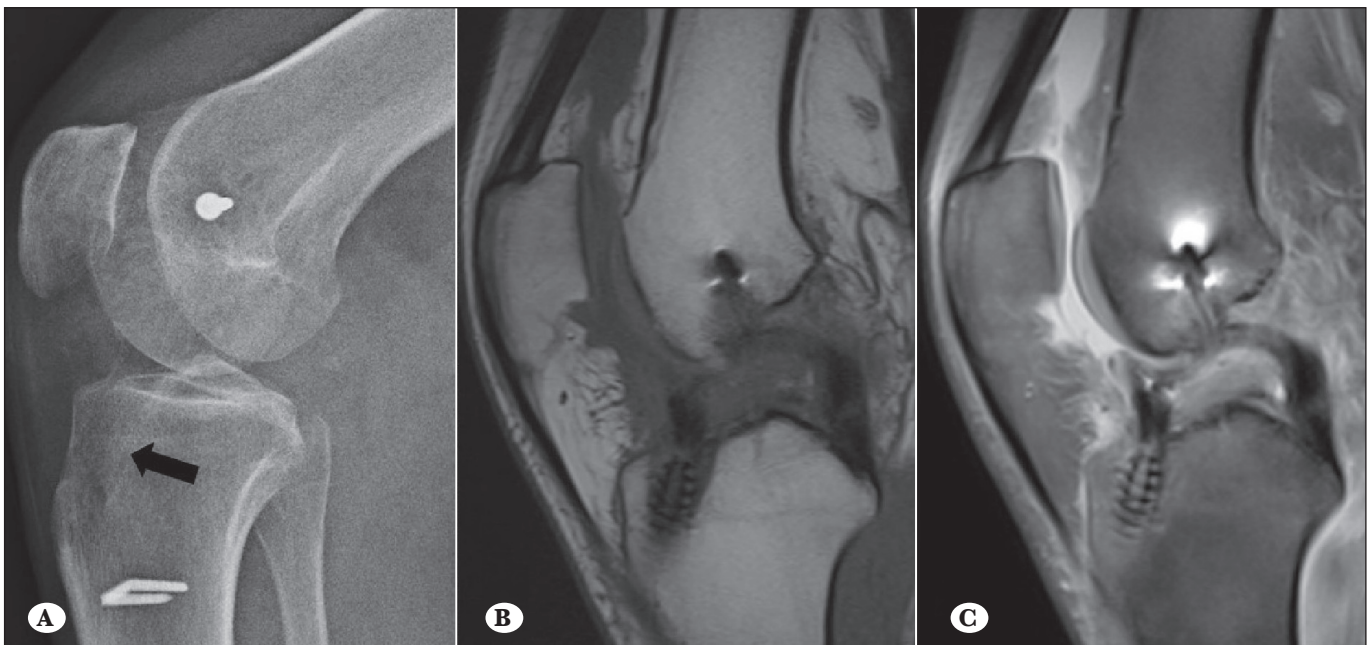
(A) Lateral X-ray image showing the anterior and vertical localization of the tibial tunnel(arrow), and the same patient's sagittal T1-weighted (B) and sagittal PD-weighted fat suppressed (C)MR images showing anterior, vertical localization of the tibial tunnel and laxity of the ACL graft.
